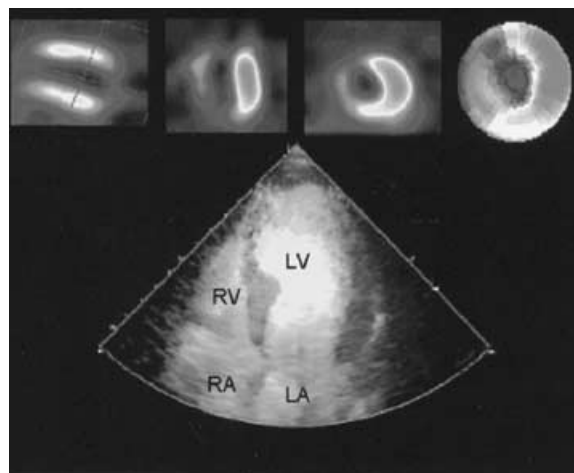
Patient with an anterior infarction with markedly reduced apical ^{99m}Tc tetrofosmin uptake on SPECT (top) and similarly reduced myocardial enhancement on harmonic power Doppler imaging (bottom). SPECT images also reveal a moderate perfusion defect in the septum, while MCE shows normal perfusion in the same territory. LA = left atrium; LV = left ventricle; MCE = myocardial contrast echocardiography; RA = right atrium; RV = right ventricle; SPECT = single photon emission computed tomography.
